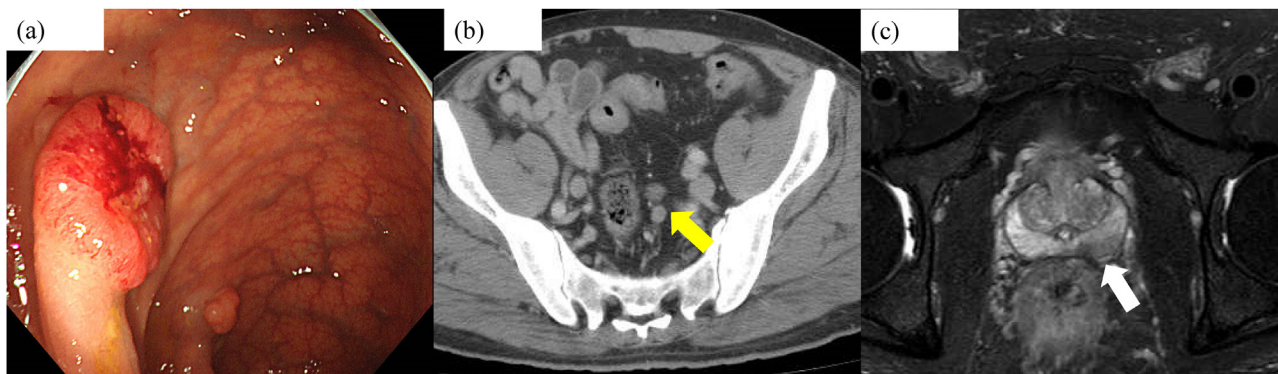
The examination of imaging before the operation in case 1. (a) Colonoscopy showed rectal cancer. (b) CT suggested lymph node metastasis (yellow arrow). (c) MRI showed prostate cancer on the left lobe (white arrow).
